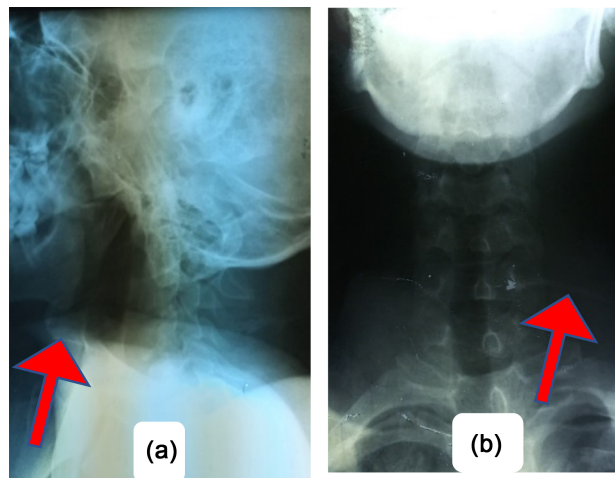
(a) profile X-ray of the neck with evidence of extra-luminal horizontal radiopaque FB opposite the 5th cervical vertebra; (b) frontal X-ray of the neck with evidence of extra-luminal horizontal radiopaque FB opposite the 4th cervical vertebra. The red arrows show a linear, thread-like, horizontal opacity suggestive of a foreign body.
